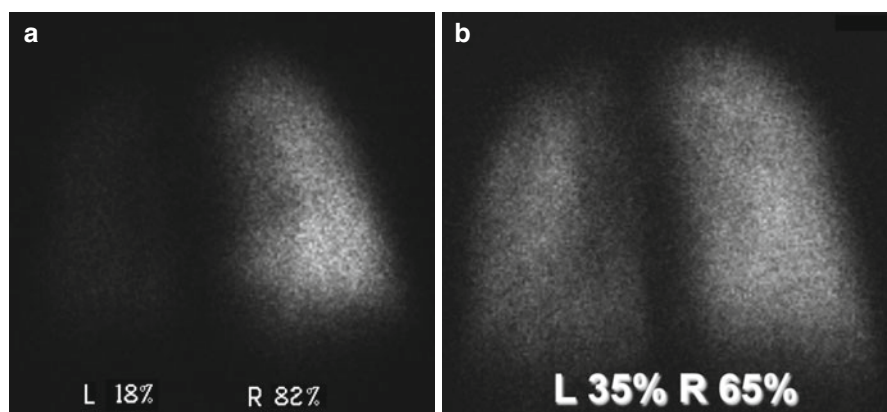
(a) Male, 6 months. Repair of tetralogy of Fallot. MAA pulmonary perfusion scintigraphy showing marked hypoperfusion of the left lung. (b) MAA pulmonary perfusion scintigraphy 3 months after percutaneous balloon angioplasty of the left pulmonary artery. Marked improvement of the perfusion in the left lung
